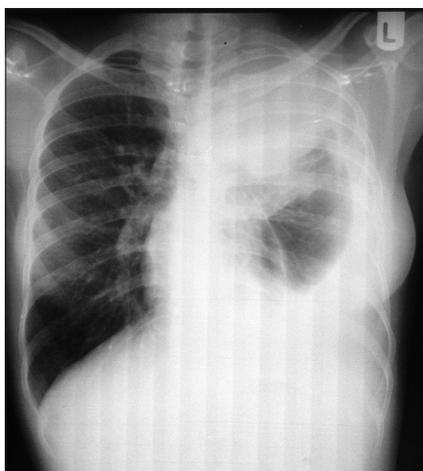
Chest X-ray showing a huge mass in the antero-superior mediastinum (postero-anterior view)
